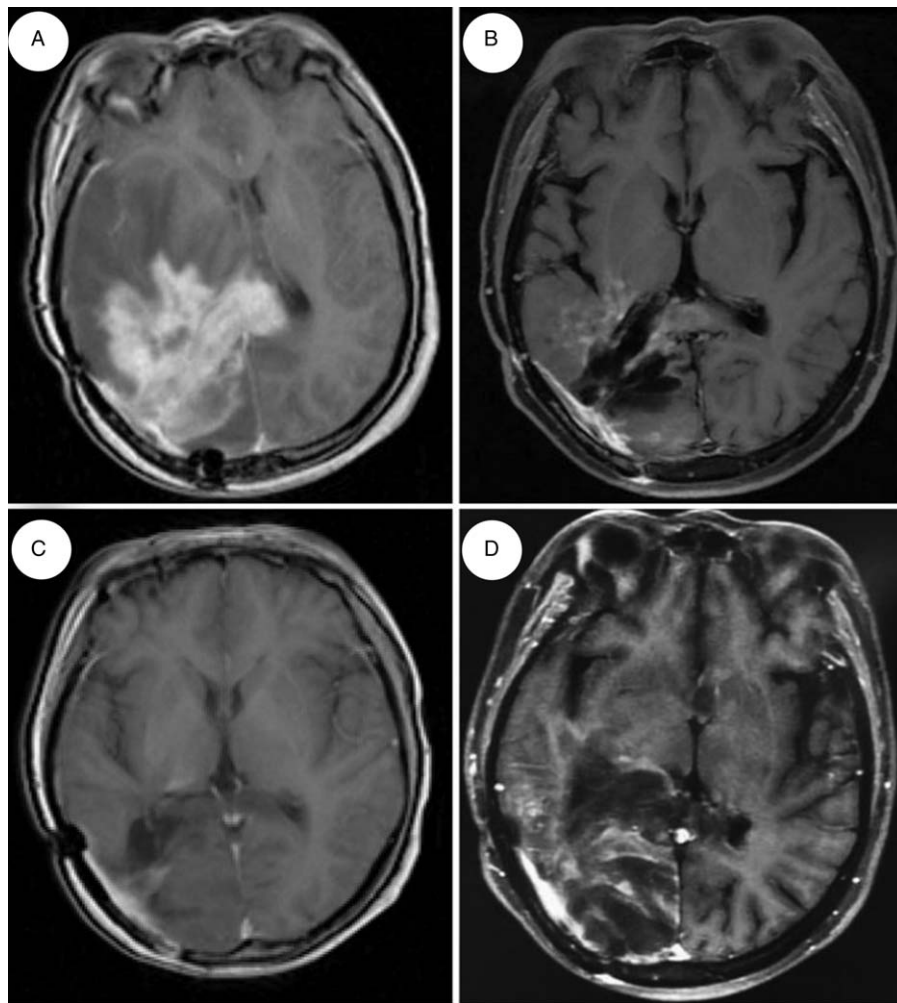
MRI of the patient (no. 2) with anaplastic astrocytoma: (A) pretreatment MRI scan; (B) posttreatment MRI scan after 3 mo; (C) posttreatment MRI scan after 4 mo; (D) posttreatment MRI scan after 9 mo. MRI=magnetic resonance imaging.
